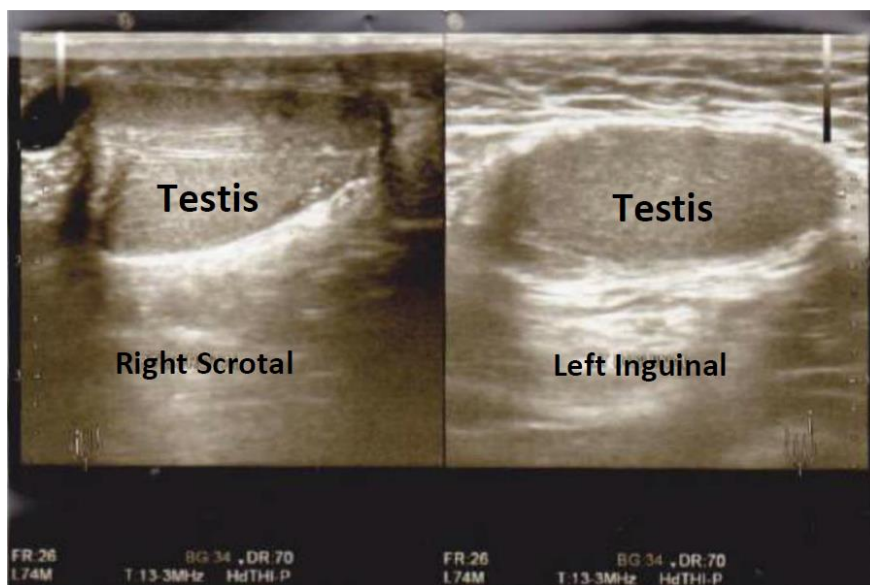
The ultrasound finding showed the right testis located in the right scrotum, while the left testis located in the left inguinal.
